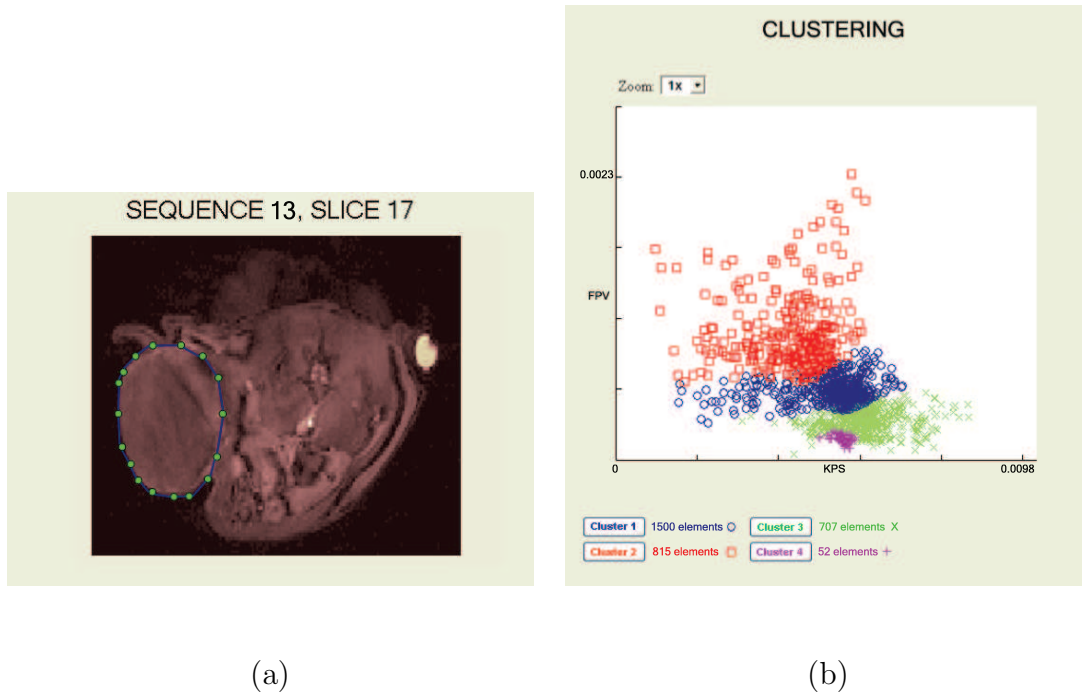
Example 2: MRI selected region (a), parameter space after clustering (b)
